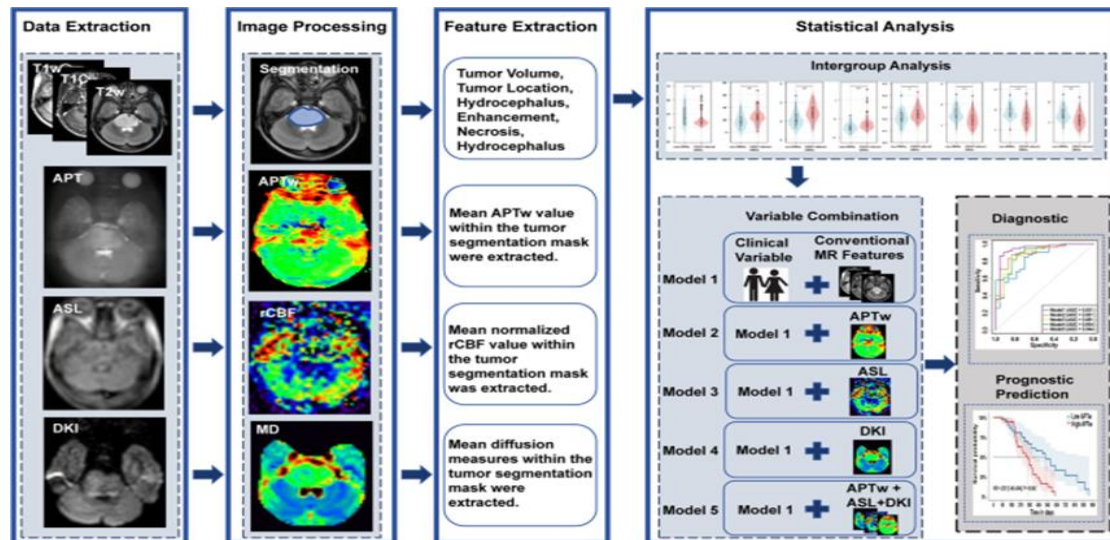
Overview of the Study. T1w: T1-weighted; T2w: T2-weighted; T1C: contrast-enhanced T1-weighted; APTw: amide proton transfer-weighted; ASL: arterial spin labeling; DKI: diffusion kurtosis imaging; rCBF: relative cerebral blood flow; MD: mean diffusivity
